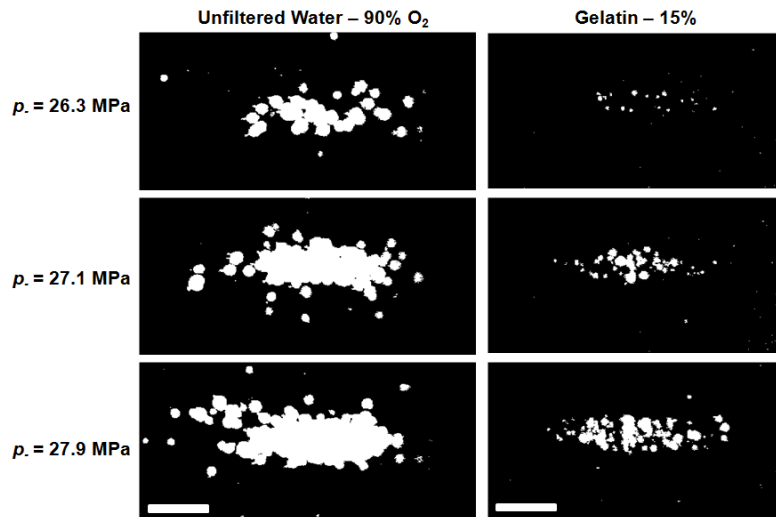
Integrated images of the locations where cavitation occurred over 100 pulses, shown in white for two materials with identical thresholds $\mu = 26.4$ MPa. Over several pulses, the positions of cavitation add to generate a pattern similar to the focal zone of the transducer. Ultrasound propagation in these images is from right to left.
